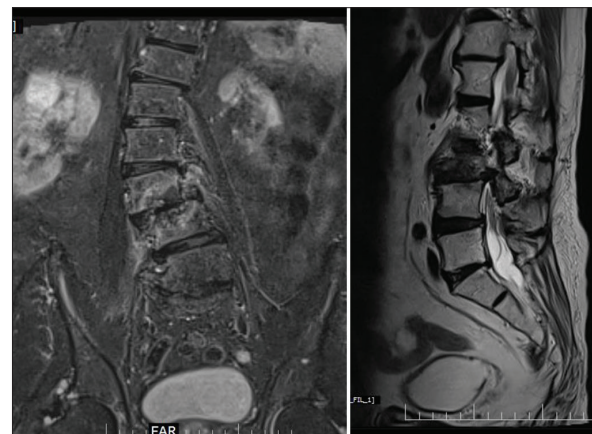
Preoperative coronal and sagittal magnetic resonance imaging sections of patient 2 showing degenerative scoliosis with lumbar canal stenosis.
